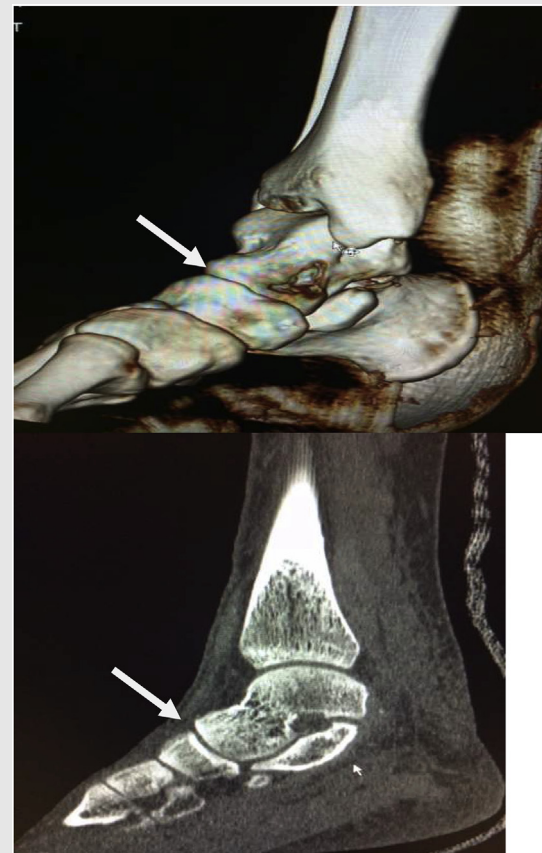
Post-reduction CT scans (white arrow: reduced talonavicular joint).
